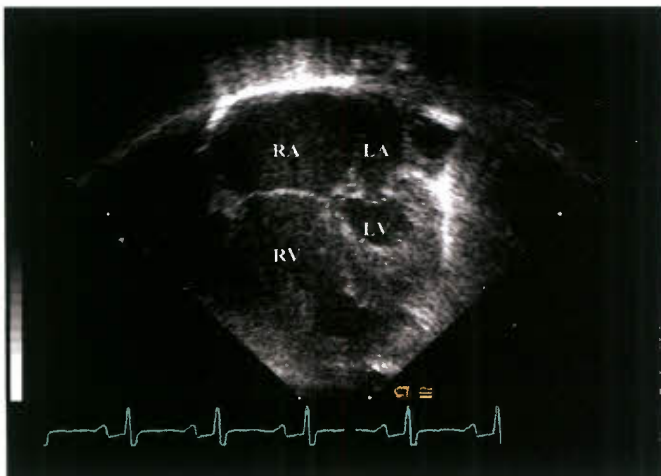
Apical four-chamber view in a patient with HLHS. The left atrium (LA) and left ventricle (LV) are much smaller than the right atrium (RA) and right ventricle (RV). The RV clearly occupies the cardiac apex.
